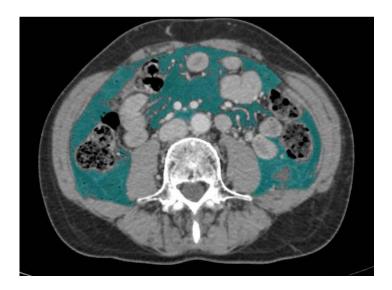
Visceral fat area measurement in CT scans.
